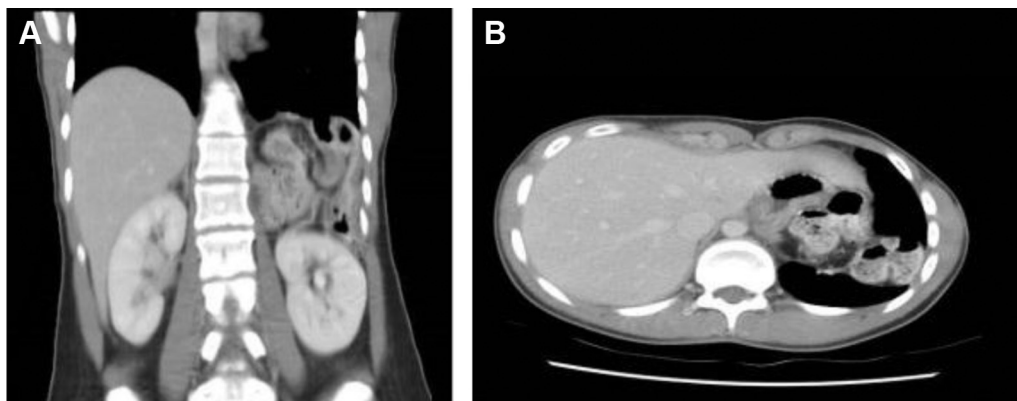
Computed tomography of chest and abdomen in (A) coronal section, and (B) transverse section prior to repeat repair, showing left diaphragmatic defect with herniated transverse colon.
